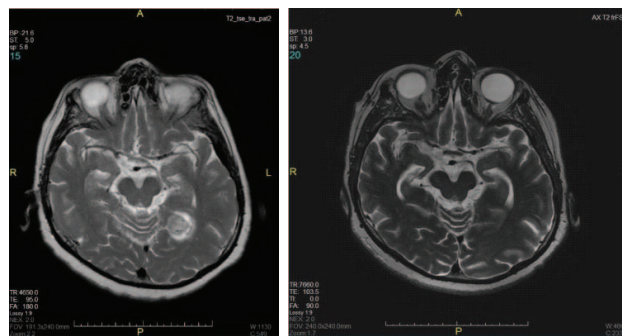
(left) T2 sequences of baseline magnetic resonance imaging (MRI) and, (right) follow-up MRI after 6 months showing a complete response (CR).
